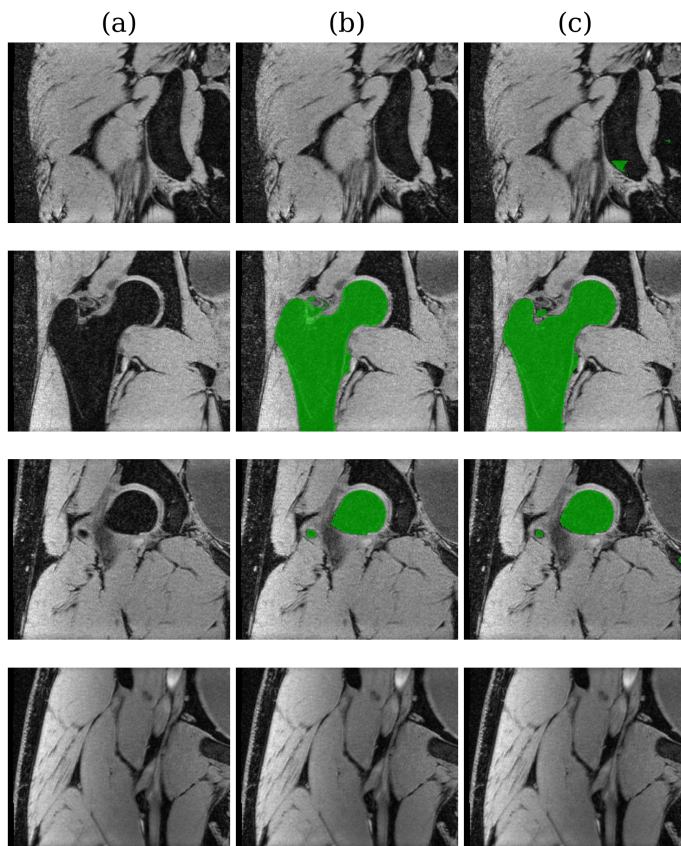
MRI slices in three columns for different anatomical views: (a) the original images without annotations, (b) manual segmentations shown in green highlighting the target structures, and (c) automatic segmentations in green for comparison with the manual annotations.
